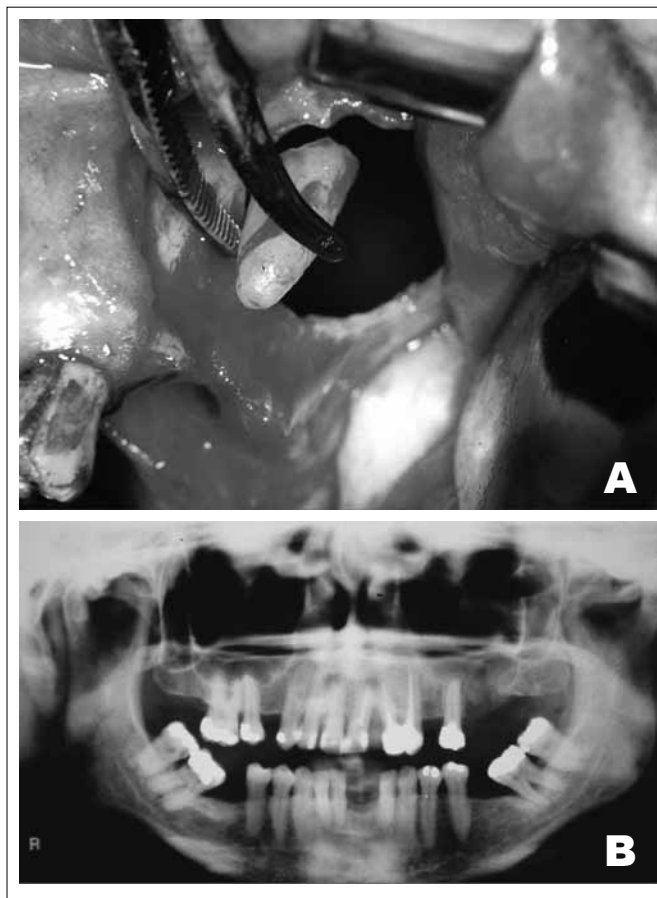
A. Root removed. B. radiographs panoramic postoperatory.
